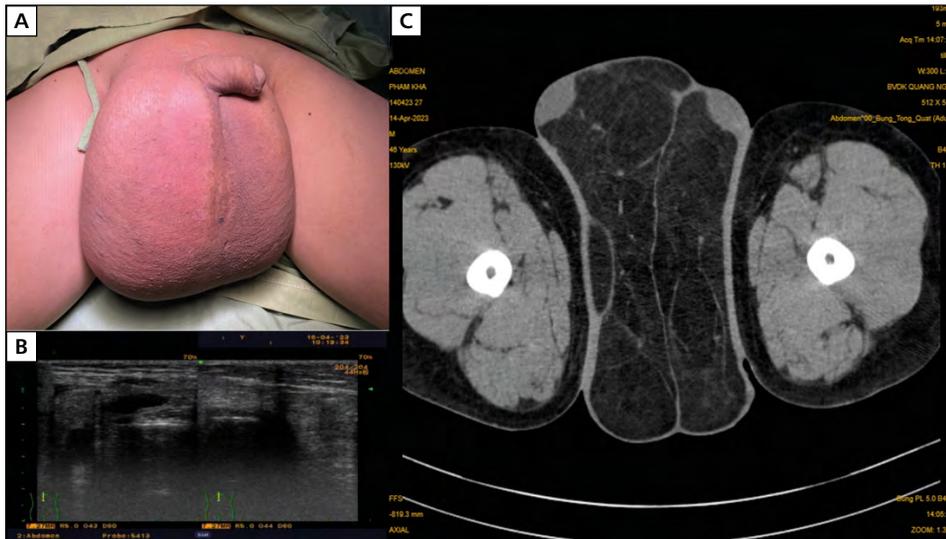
Clinical aspect, ultrasound and computed tomography (CT) images of the tumor; A. Visible scrotal mass; B. Ultrasonography showed a slightly higher echogenic mass; C. CT scan revealed multilobulated fatty mass in the scrotum
